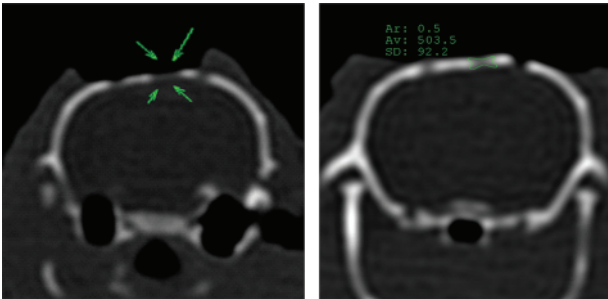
Density measurement of newly formed bone on computed tomography images.
